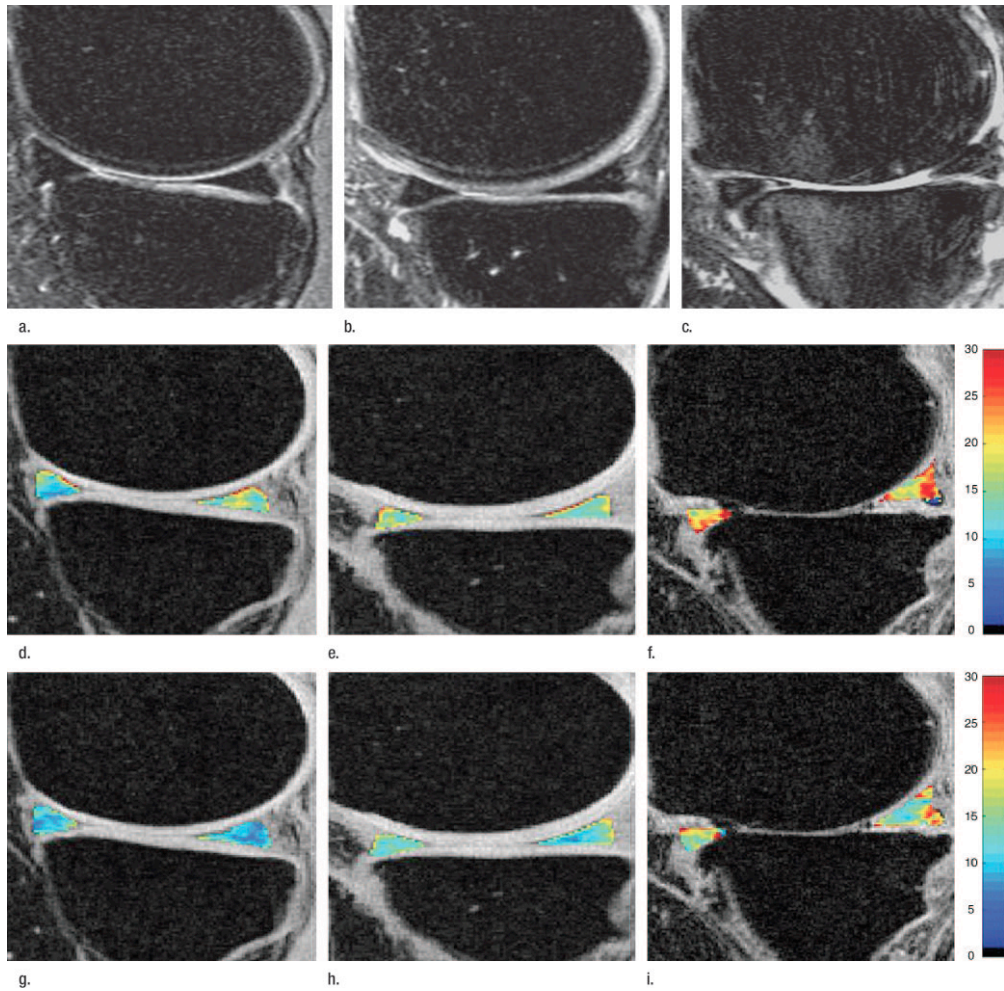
Representative MR images show medial meniscus in (a, d, g) a healthy subject, (b, e, h) a patient with mild OA, and (c, f, i) a patient with severe OA. (a– c) Fast spin-echo images (4300/51) show morphology of the menisci. In a and b, the meniscus appears normal, but c shows a tear in the anterior and posterior horns of the medial meniscus. corresponding (d–f) T1 (in milliseconds) and (g–i) T2 (in milliseconds) color maps overlaid on SPGR images (20/7.5, 12° flip angle) clearly show differences in the meniscal matrix among the three subjects. *From Rauscher et al. Meniscal Measurements of T1rho and T2 at MR Imaging in Healthy Subjects and Patients with Osteoarthritis. Radiology. 2008.*
